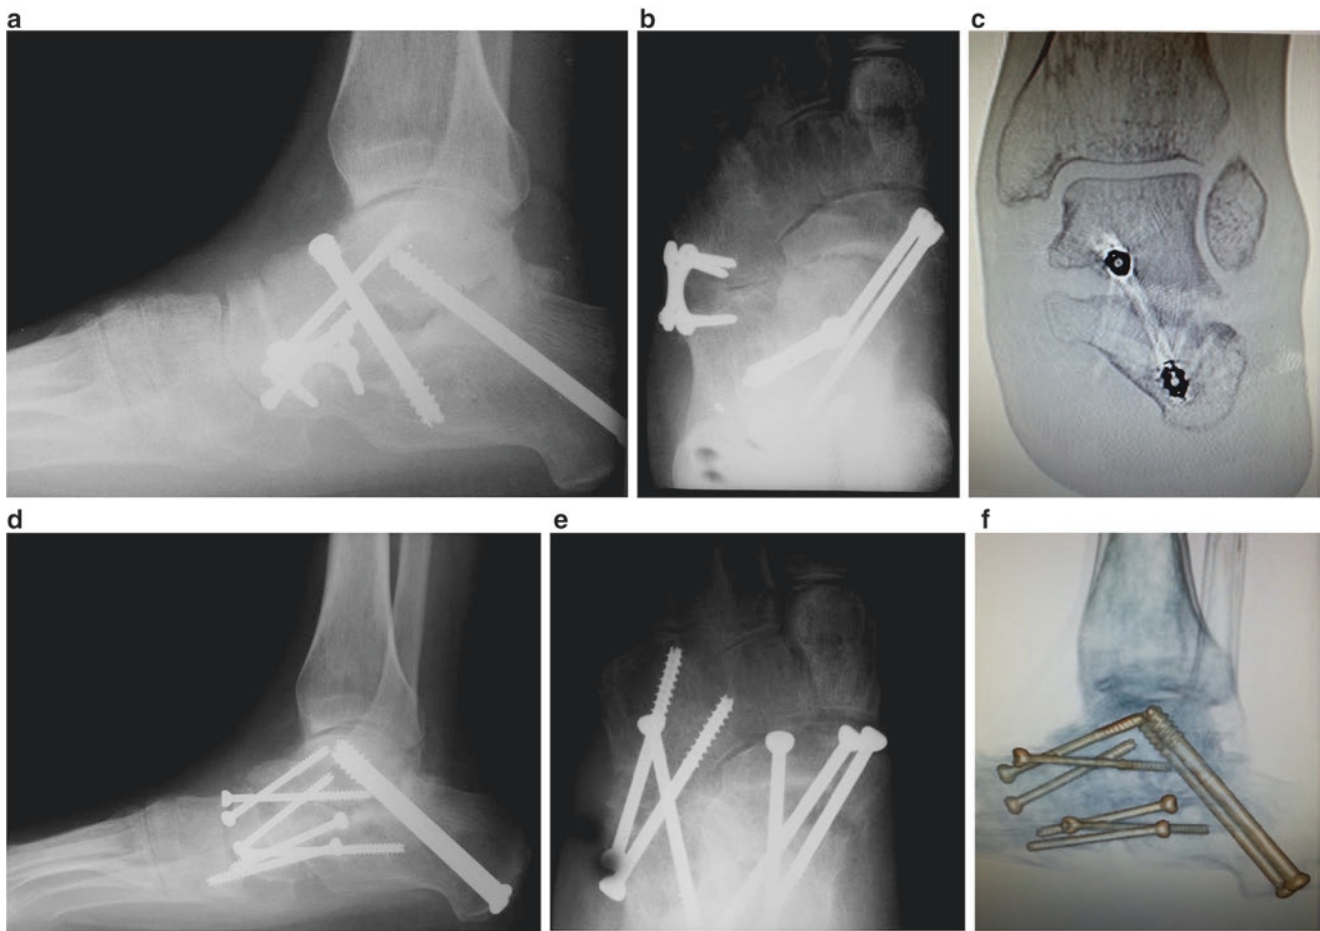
(a, b) Radiographs demonstrating nonunion of all tritarsal joints following triple arthrodesis. (c) CT scan confirmation of nonunion. (d, e) Status post revisional triple arthrodesis. Note 2-point fixation of all tritarsal joints. (f) CT scan confirmation of consolidation
